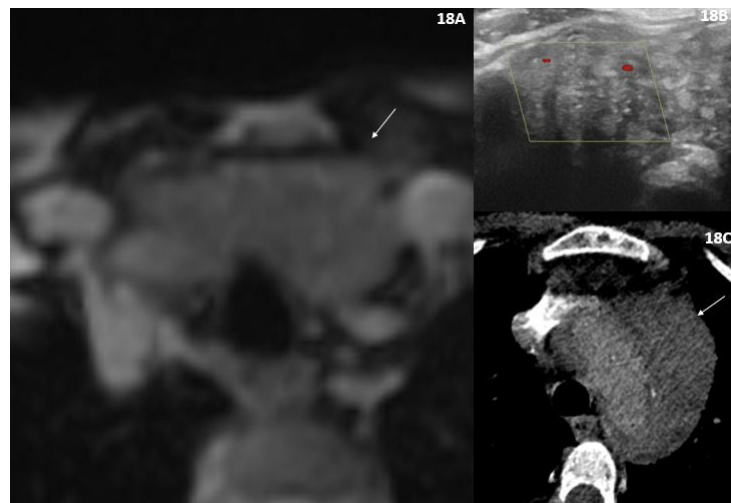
Case 4. A) Enlarged thyroid gland with mediastinal extension shown in post-contrast MRI images. B) USG image showing heterogeneous echotexture of enlarged thyroid gland with mild increased vascularity. C) Periaortic soft tissue lesion along the aortic arch in post-contrast CT image
